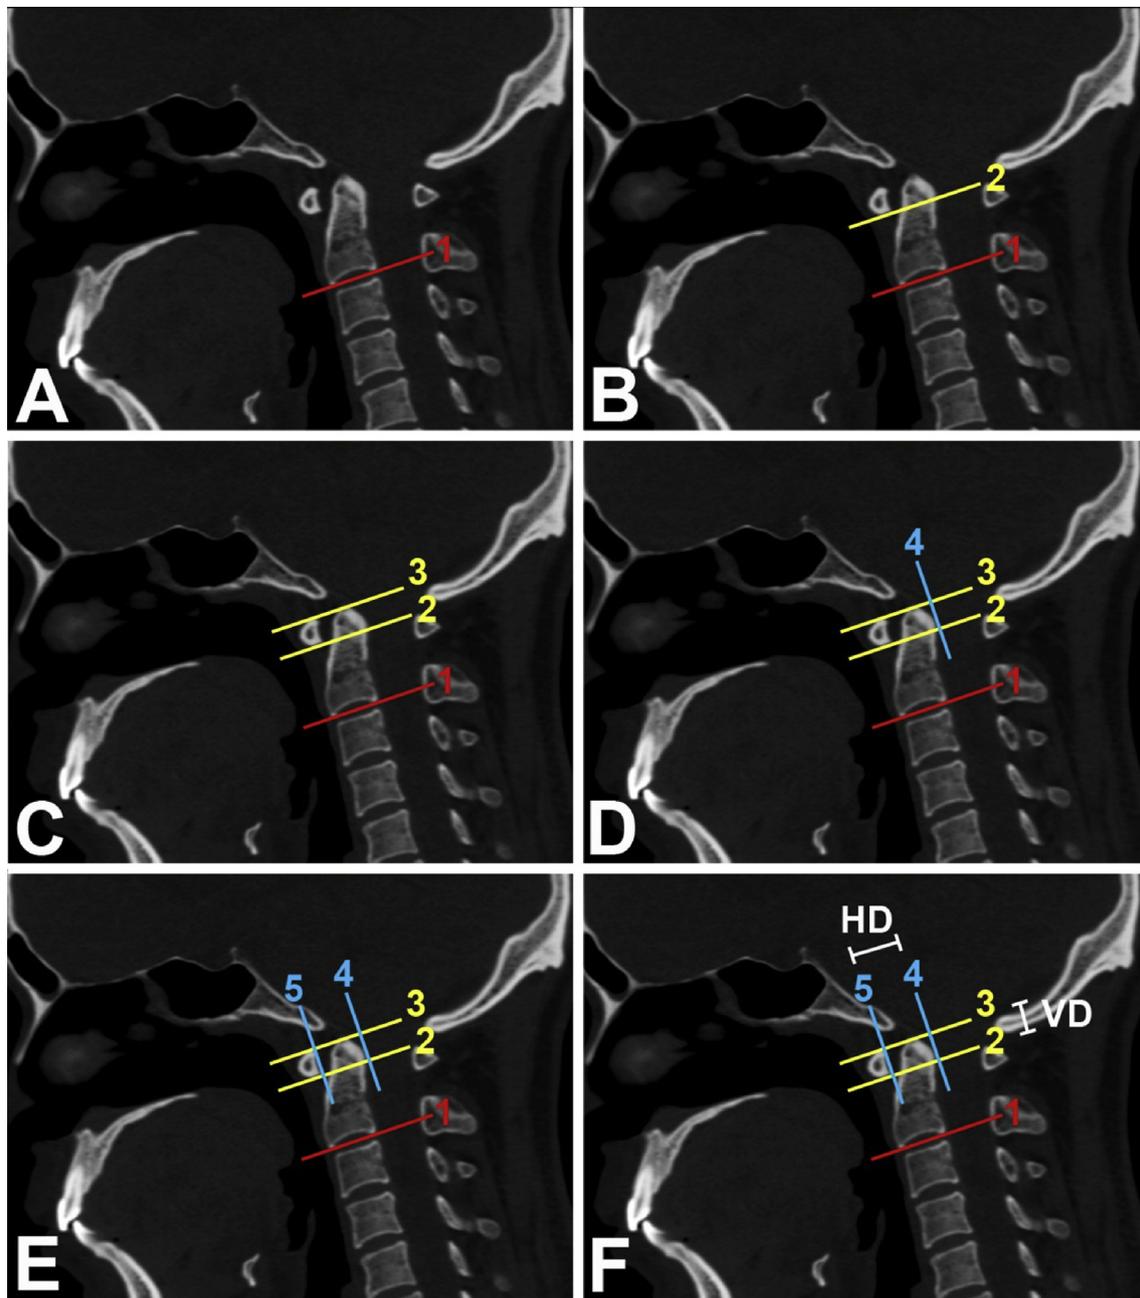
Preoperative sagittal computed tomography (CT) scans demonstrating the required lines to measure the vertico-horizontal atlantoaxial index (VHAI) in a case of congenital basilar invagination with atlantoaxial dislocation. VD: vertical displacement, HD: horizontal displacement.
